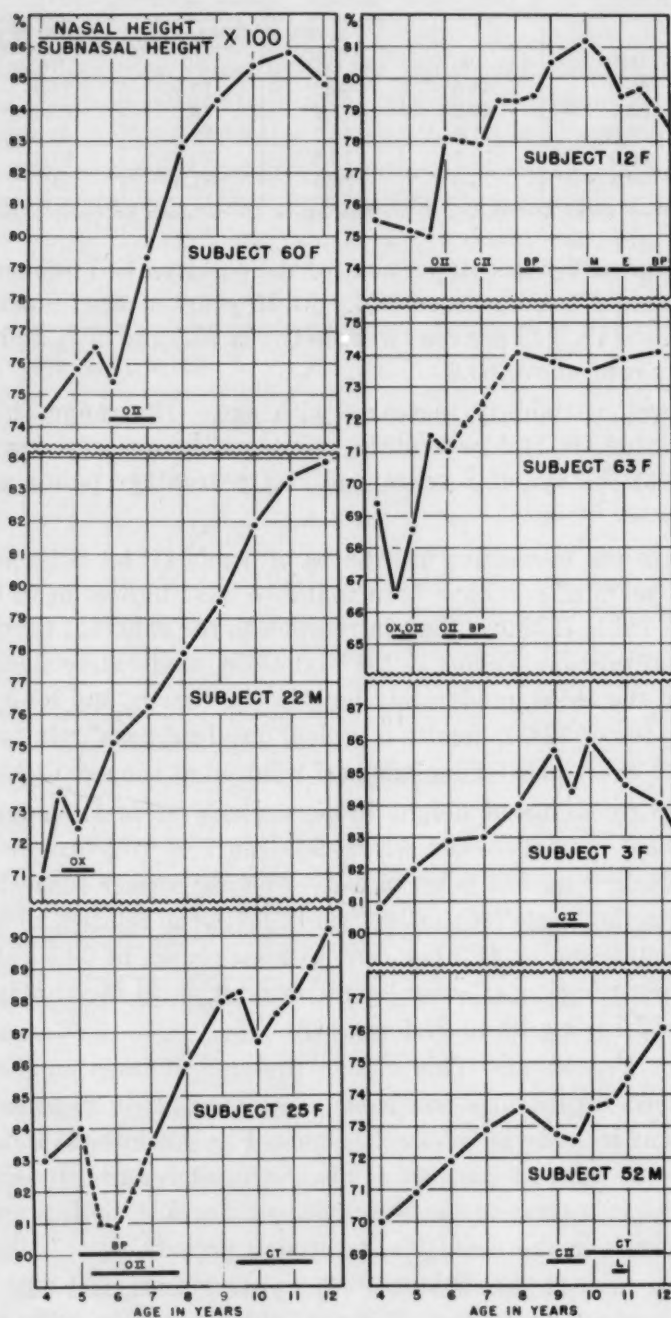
Individual curves for seven children receiving "bite-opening" therapy. *OII*, Overlay crowns on deciduous molars for Class II elastics; *OX*, overlay crowns on deciduous molars for cross-bite; *BP*, bite plate; *CT*, cervical traction; *OII*, Class II elastic traction; *M*, monoblock (Andresen); *E*, extraction (premolar) with retraction of anterior teeth; *L*, leveling arch wires. Black triangle indicates point obtained with subject wearing bite plate.
